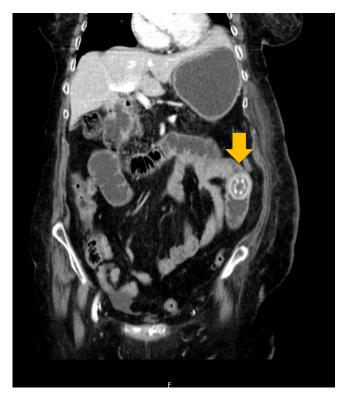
Contrast-enhanced CT showing a 30-mm stone causing dilation of the small intestine loops (arrow).
